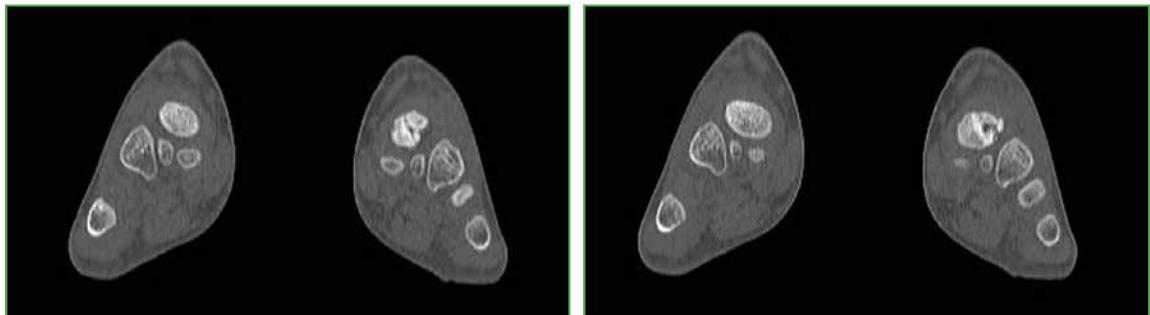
Computed tomography coronal reconstruction image of both feet. Compare the morphological characteristics of both navicular bones. Right navicular shows no abnormalities.
